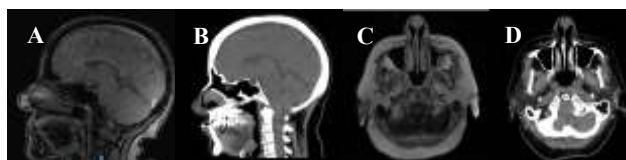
(A-D): Imaging findings of a nasal vestibular schwannoma. Sagittal MRI shows a well-circumscribed soft-tissue mass arising from the nasal vestibule. Sagittal CT demonstrates a soft-tissue lesion without significant bony erosion. Axial MRI reveals a homogeneous, contrast-enhancing mass in the anterior nasal cavity. Axial CT delineates the lesion's anatomical relationship with the nasal septum, turbinates, and surrounding soft tissues.
